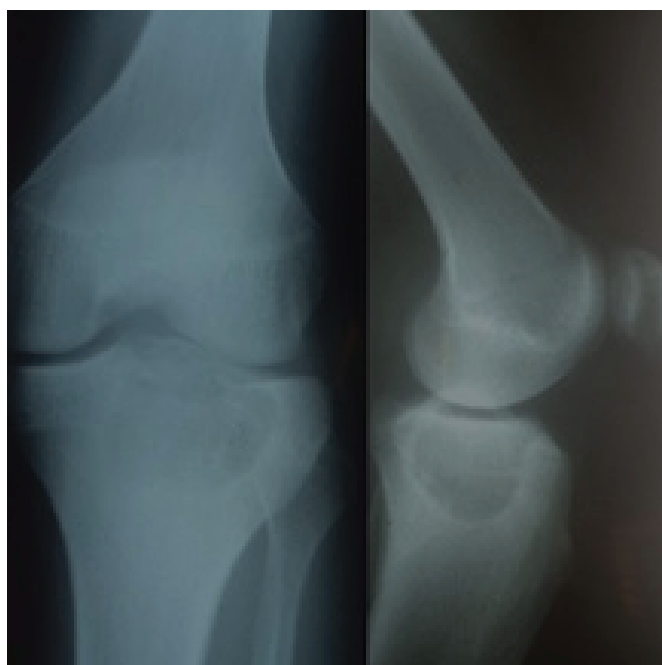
Anterior posterior and lateral radiograph of the left knee showing eccentric lytic epimetaphyseal lesion.
